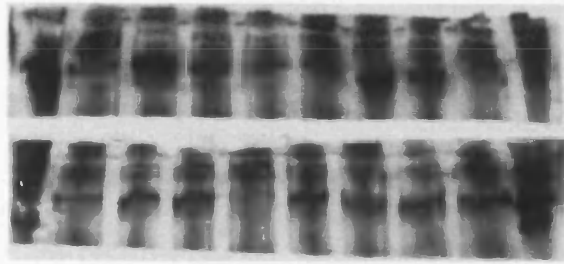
Example of Western Blot for β -catenin. Blotting for β -Catenin following one second exposure on the X-ray film. Bands were visible at ~94 kDa.
